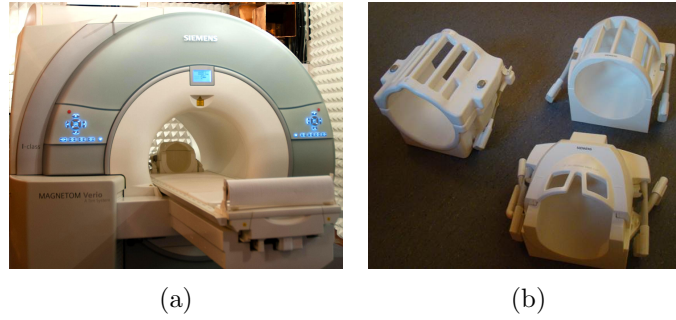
(a) 3T MRI scanner at IRIS platform in ICube laboratory, (b) Head antenna (RF coils)
